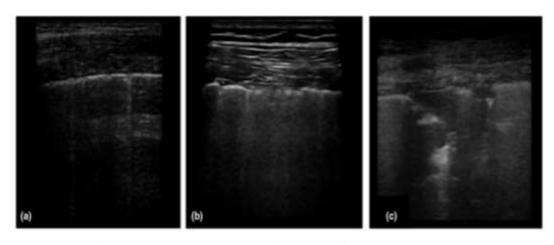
Patterns of COVID-19 at chest ultrasound. Early bilateral multifocal areas of interstitial syndrome. Interstitial pneumonia characterized by interstitial syndrome with B lines and preserved sliding sign. Advanced, organized pneumonia with interstitial syndrome associated with multiple subpleural consolidations and reduced sliding sign.
